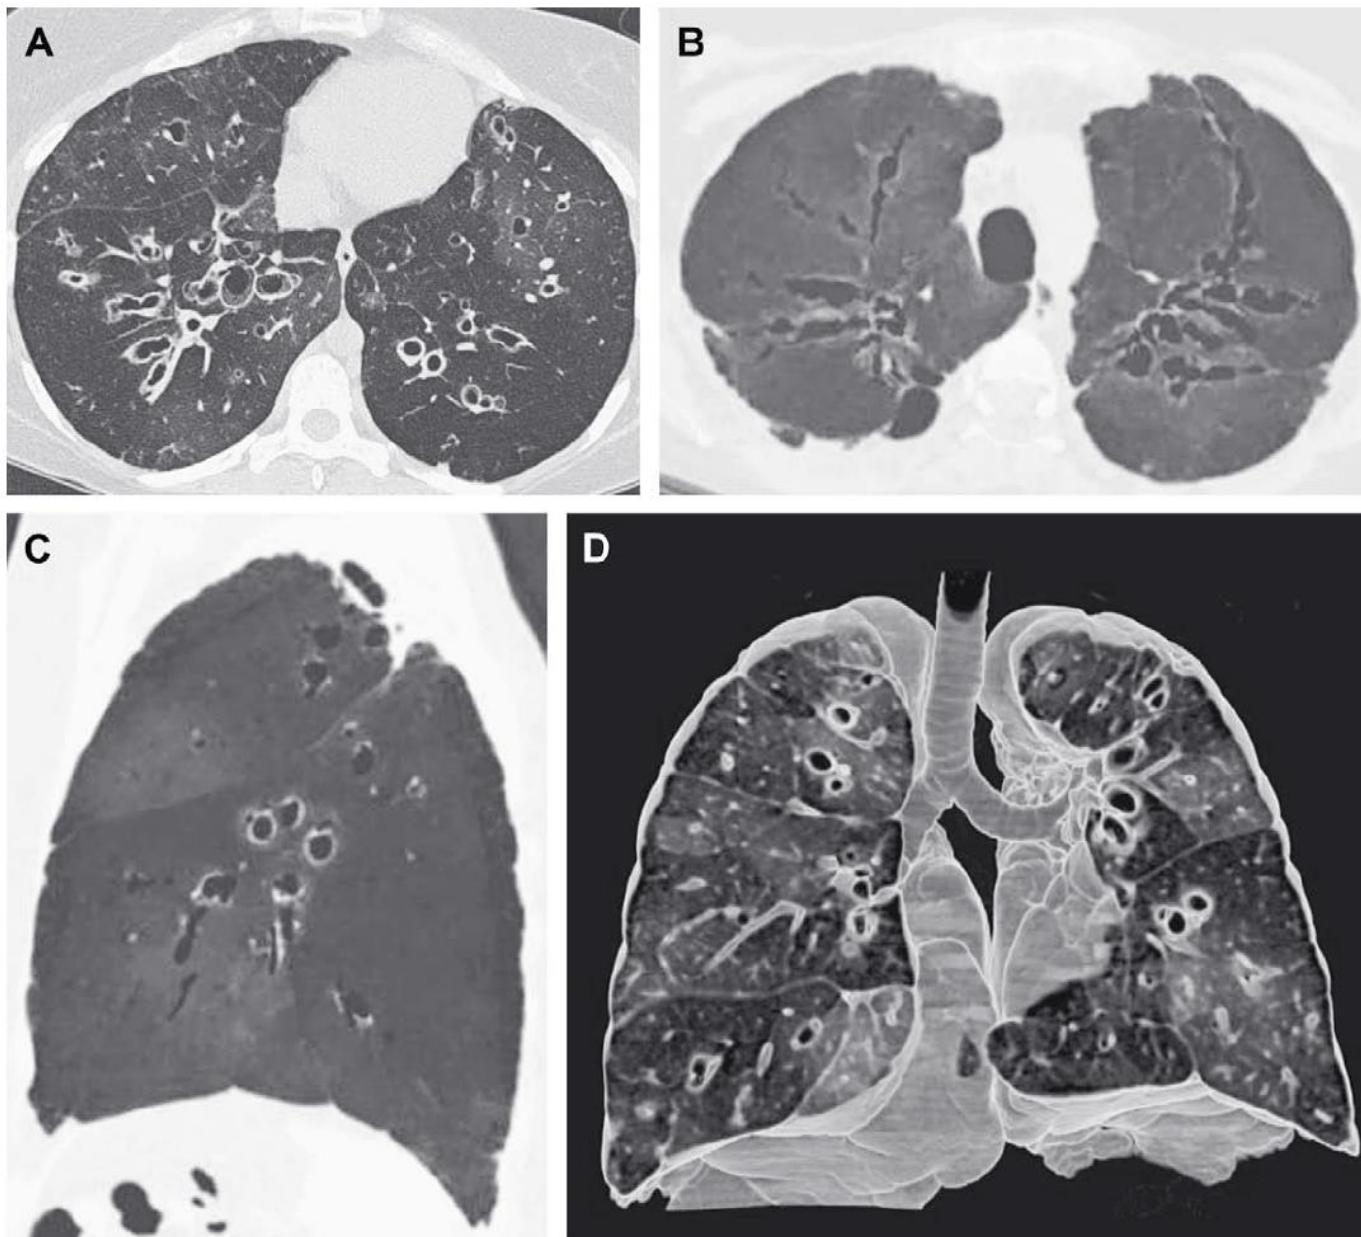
Primary ciliary dyskinesia: a 37-year-old woman with primary ciliary dyskinesia and chronic pseudomonas aeruginosa infection being evaluated for bilateral lung transplantation. HRCT of chest (A) shows mixed tubular, varicose, and cystic bronchiectasis. Minimal intensity reformatted images in axial (B) and sagittal (C) planes and volume-rendered image (D) demonstrate the extent of bronchiectasis and the associated mosaic attenuation.
